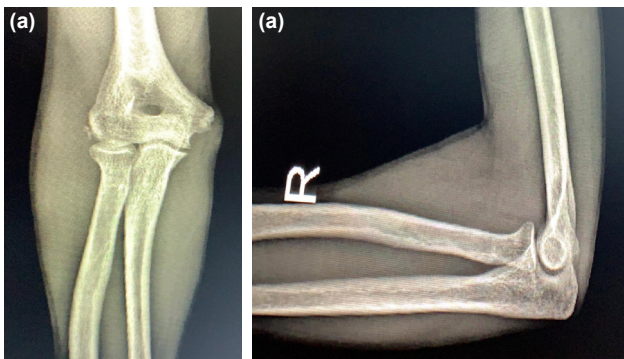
Complete fracture union noted on anteroposterior (a) and lateral (b) radiographs at the 6-month follow-up.
